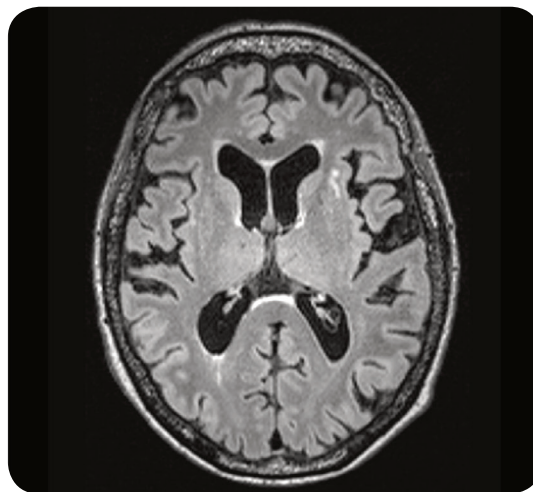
An MRI scan in the axial plane demonstrating prominent sulci and gyri in an individual with Alzheimer's disease.
